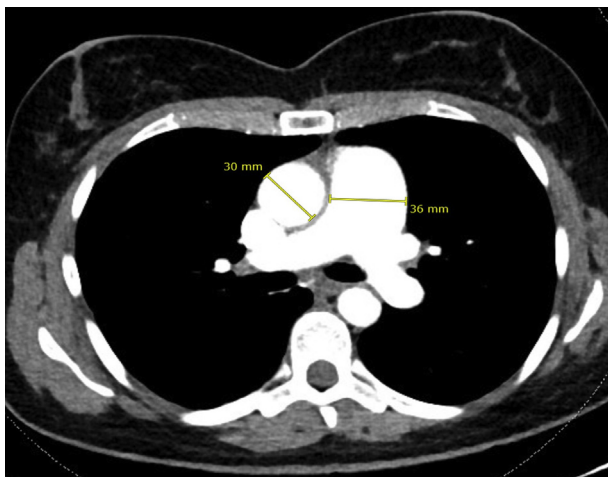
Example of measurement of the vessels in an axial computed tomography (CT) scan at the level of the pulmonary trunk.
